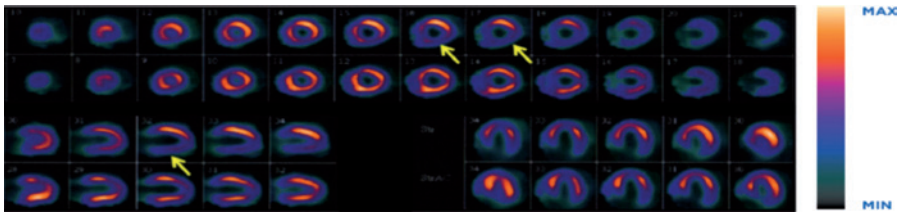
AC and non-AC images obtained with a SPECT/CT full-time acquisition.
